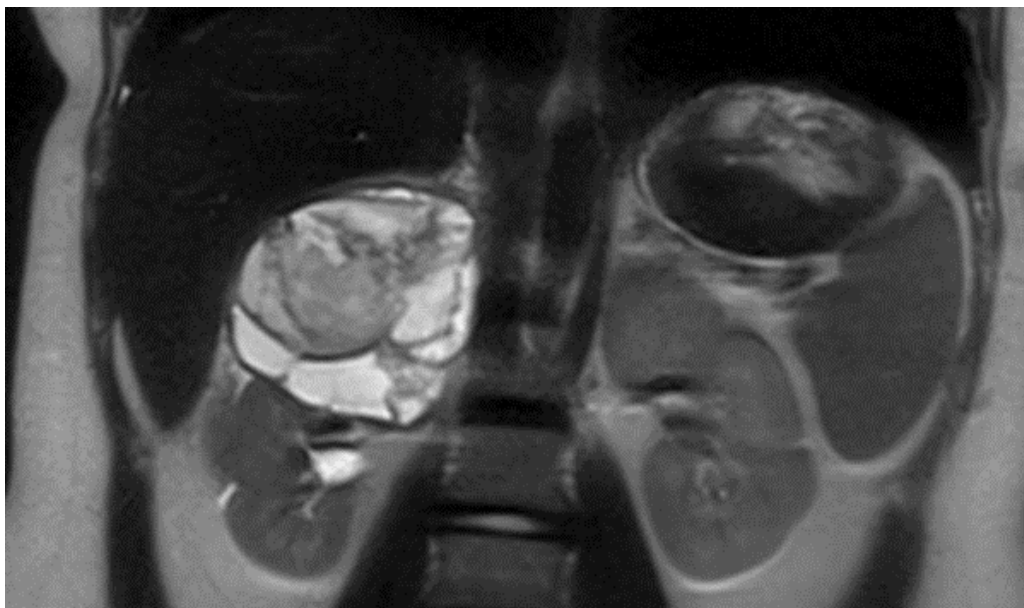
MRI view of tumor formation with cystic appearance in right adrenal gland
